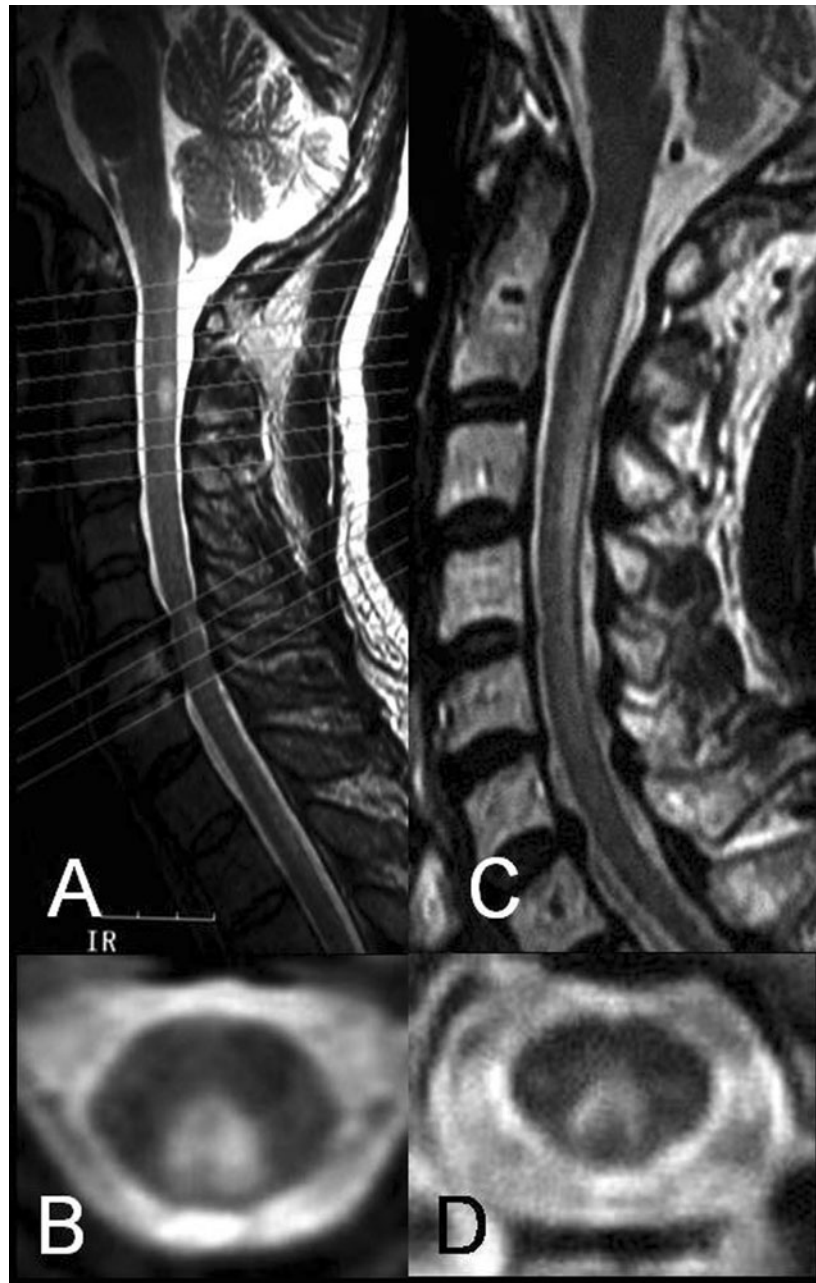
Spinal cord MRI from patients 7 (A, B) and 8 (C, D). Sagittal T2WI revealed high intensity lesions at C2–3 levels in patient 7 (A) and at C1–4 levels in patient 8 (C). Axial T2WI (B, D) revealed bilateral high intensity lesions in the posterior columns.
